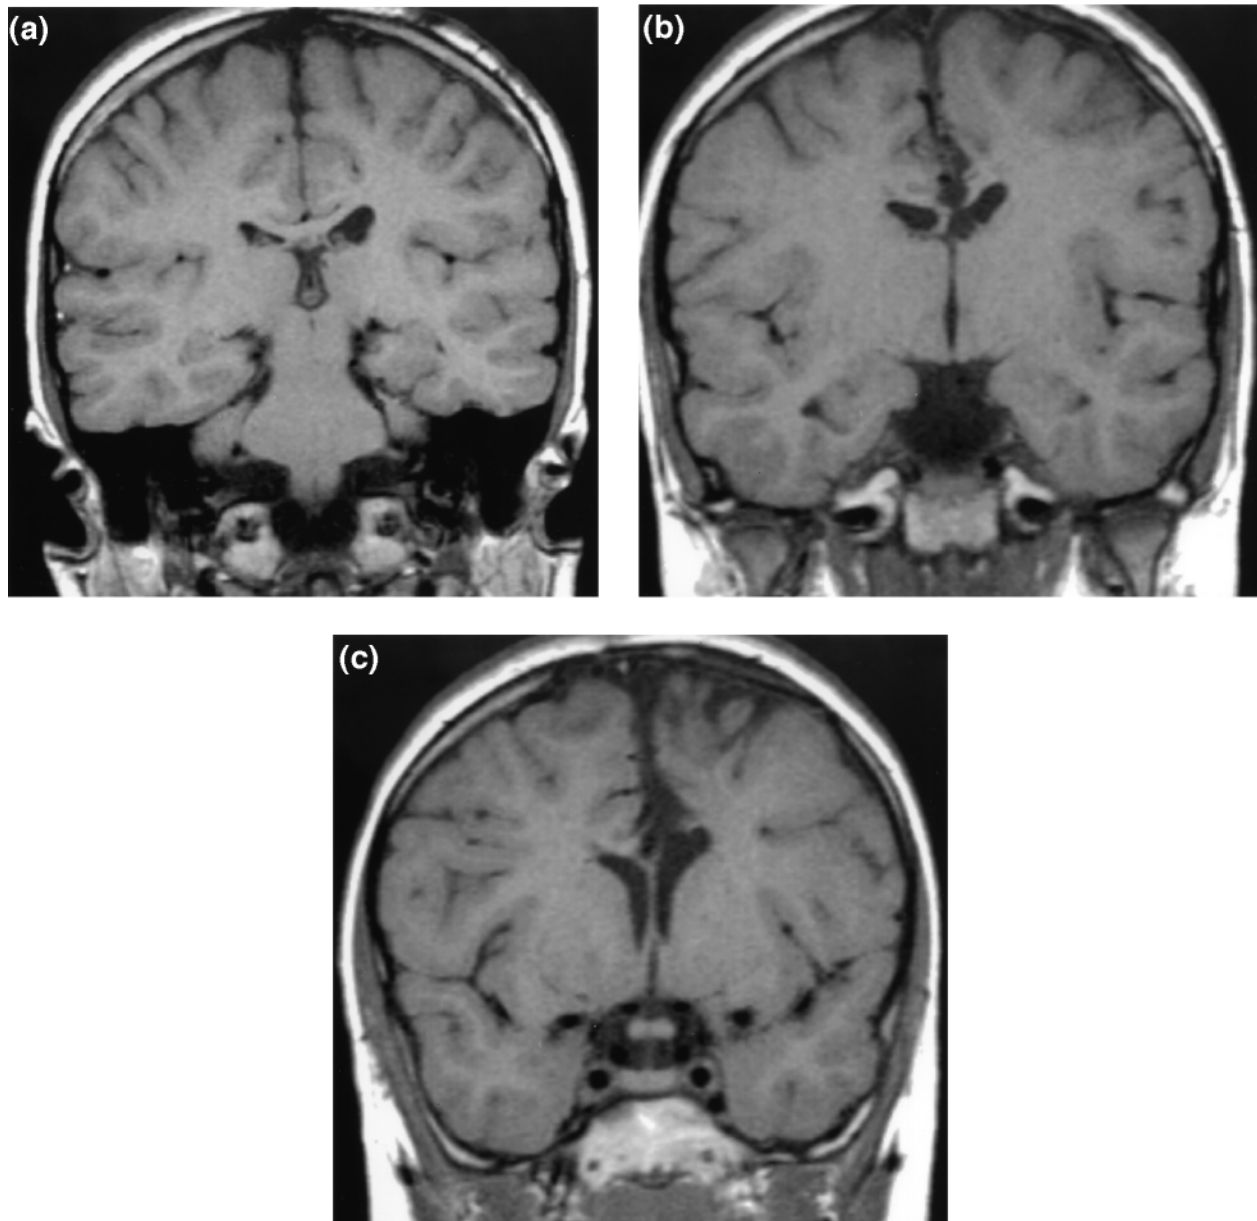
Coronal brain sections from CA's post-operative non-contrast magnetic resonance image from June 1994, 13 months following the last surgery. (a) Posterior to appearance of lesion, (b) transitional zone demonstrating the pericallosal arteriovenous malformation and absence of left fornix, (c) anterior view demonstrating the extensive lesion and loss of the anterior corpus callosum.
